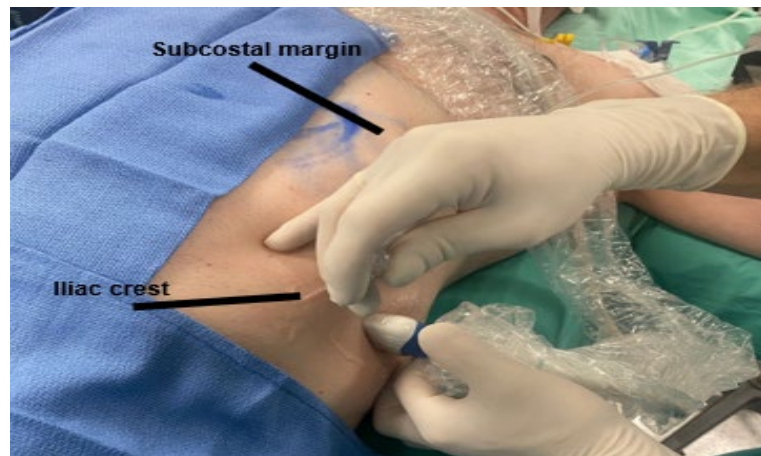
Ultrasound transducer was placed in the transverse plane at the mid-axillary line between the lower costal margin and the iliac crest.
